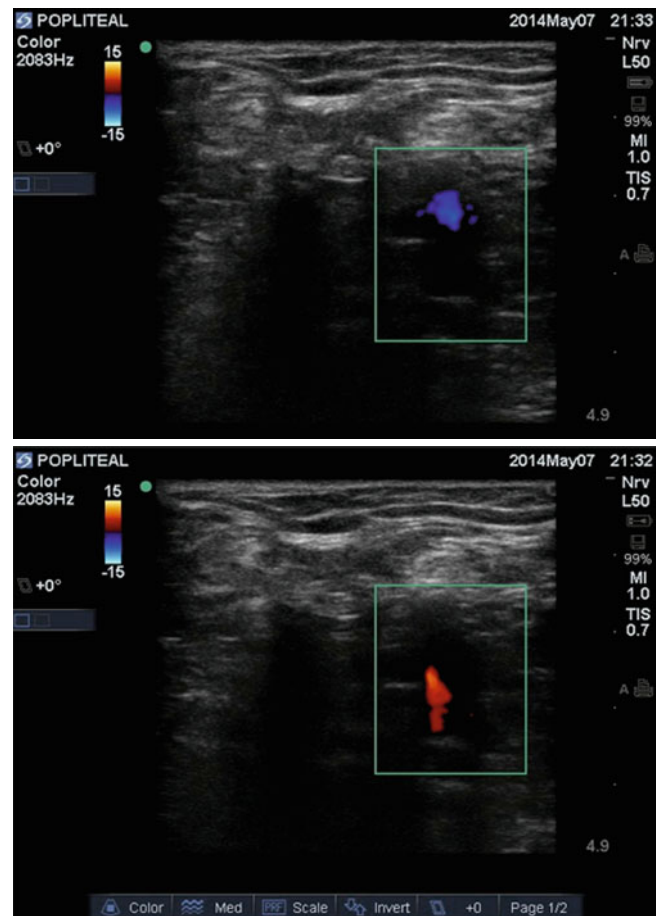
Color Doppler may be used to help identify the popliteal vein (*upper image*) and artery (*lower image*) (With permission from Dr. Ki Jinn Chin)
